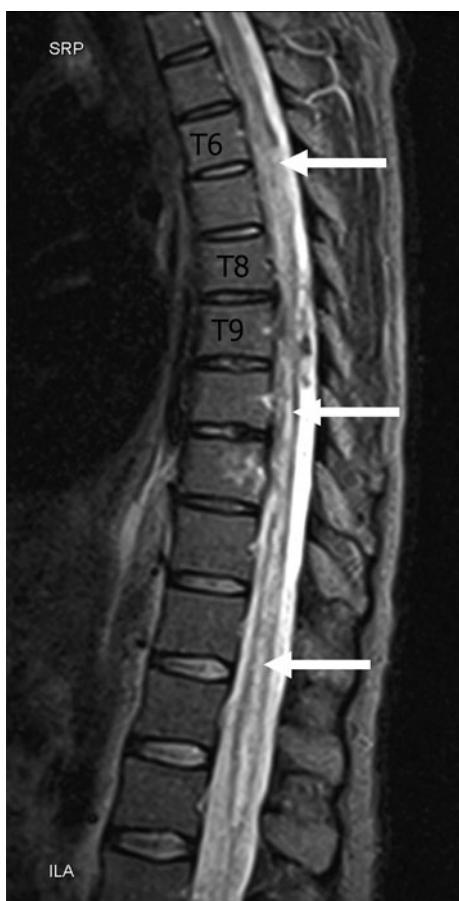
An MRI performed 15 days after the beginning of the symptoms revealed a diffuse spinal cord ischemia from T6 to the conus medullaris (arrows)
